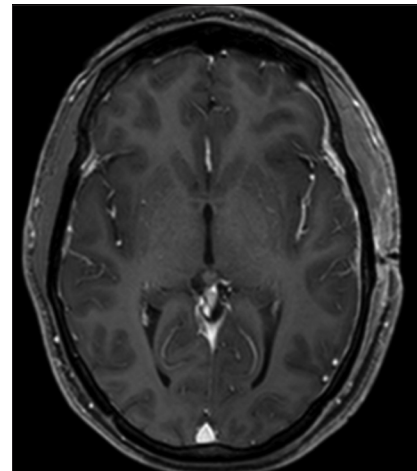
Postoperative T1-weighted enhanced brain magnetic resonance (MR) imaging. The postoperative brain MR performed with gadolinium diethylenetriaminepentaacetic acid was negative.
